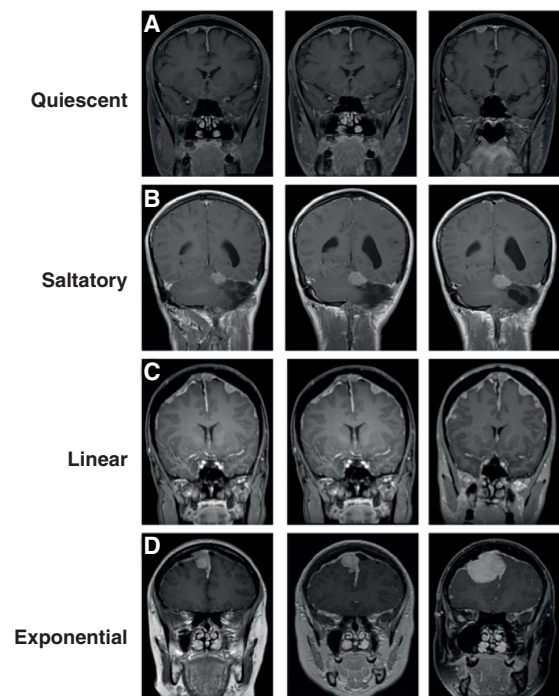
Natural history of NF2-associated meningioma. Each row depicts T1 weighted, contrast-enhanced coronal MRI scans of the brain from patients with NF2-schwannomatosis. Each scan undertaken one year apart, with the most recent scan on the right. (A) Quiescent: Right convexity meningioma demonstrating no significant change in volume during follow-up. (B) Saltatory: Left tentorial meningioma demonstrating an initial volume increase between the first and second scans, with subsequent stabilization. (C) Linear: Slowly progressive increase in volume of multiple convexity and parasagittal meningioma during follow-up. (D) Exponential: A right parasagittal meningioma demonstrating a small increase in tumor volume between the first and second scans, with a subsequent dramatic increase in volume one year later, leading to the development of neurological deficits and necessitating surgical resection.
